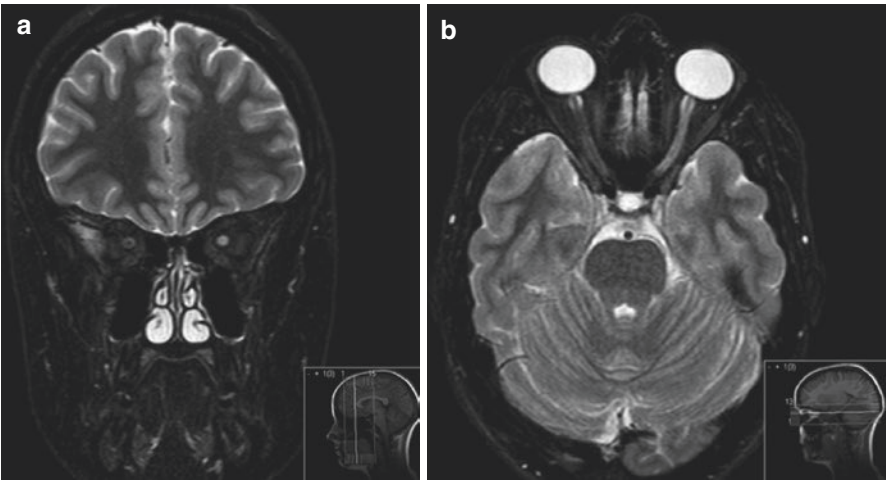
MRI: coronal (a) and axial (b) T2 weighted scans showing a high signal lesion within the left optic nerve
